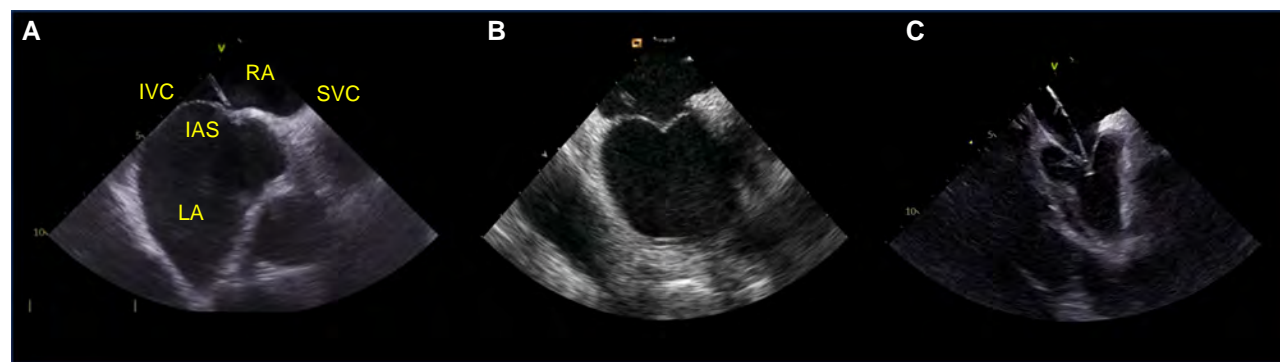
Intracardiac echocardiography to guide TSP. (A) The interatrial septum is visualized from the mid-right atrium (RA) position, applying posterior deflection of the posterior-anterior knob and applying slight rightward rotation of the right-left knob which identifies the superior (SVC) and inferior (IVC) venae cavae as landmarks of the superior and inferior borders of the septum. In (B), central position of the needle in the fossa ovalis is visualized, allowing for direct imaging of puncture height. (C) Septum tenting and finally crossing of the needle is visualized in real-time. IAS, inter-atrial septum; IVC, inferior vena cava; LA, left atrium; RA, right atrium; SVC, superior vena cava.
